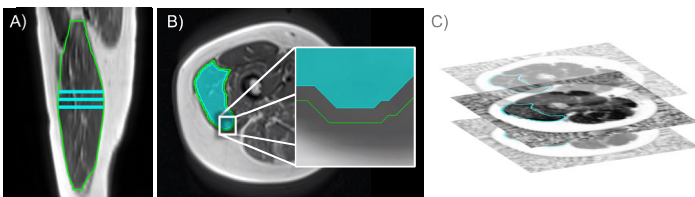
ROIs were produced from 3-slices centered on the muscle (A) segmented on T1-weighted images with an axial contraction (B) that was co-registered with the MRI-PDFF map (C)
